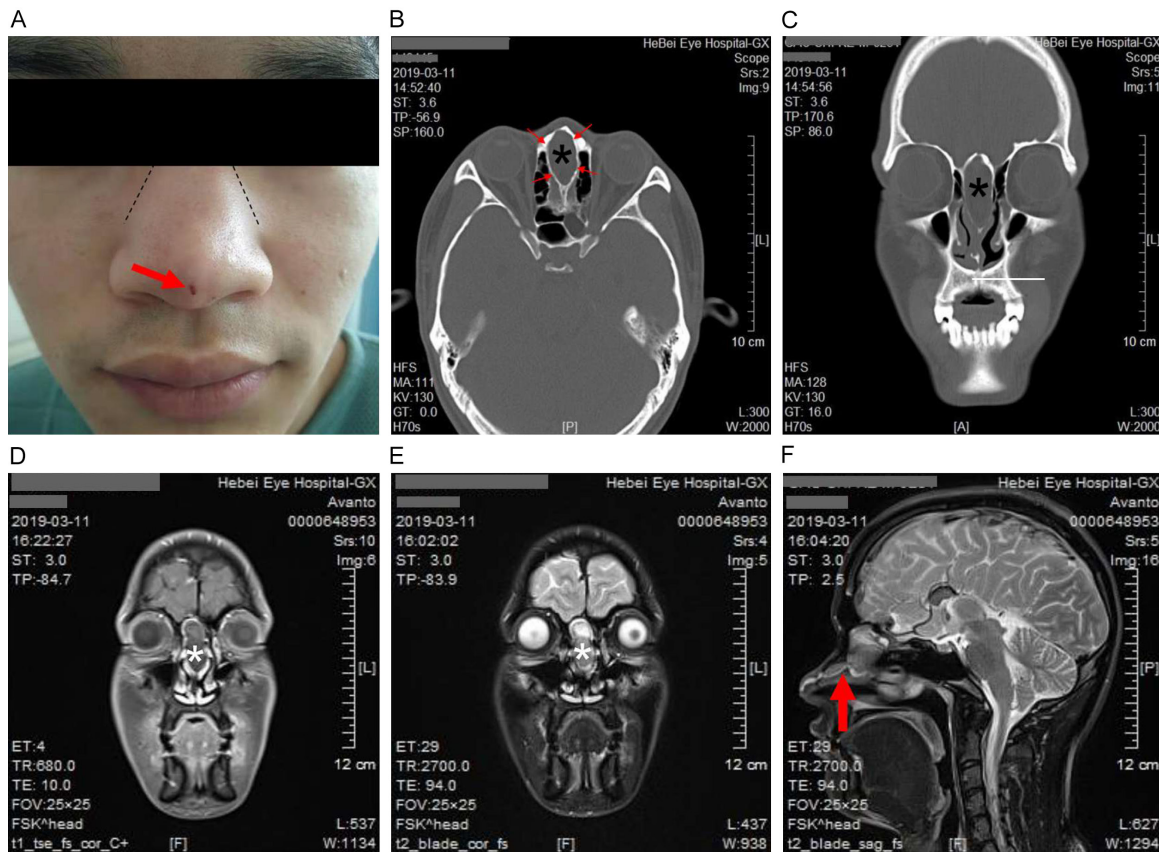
Preoperative clinical findings and multimodal imaging evaluation. A. Black dashed lines delineate expansion of the nasal dorsum overlying the mass. The red arrow indicates a small midline fistula at the nasal tip, representing the external opening of the congenital sinus tract; B. Axial CT image shows an expansive, oval-shaped, low-density lesion (asterisk) in the nasal septum. Red arrows indicate the intact bony shell surrounding the mass. C. Coronal CT view shows a large cyst (asterisk) occupying the perpendicular plate of the ethmoid bone, with marked bilateral septal bulging and narrowing of the nasal airway; D. Coronal contrast-enhanced T1WI displays a non-enhancing midline mass (asterisk); E. Coronal T2WI-fat-suppressed image (T2WI-FS) demonstrates a hyperintense cystic lesion (asterisk); F. Sagittal T2WI image indicates a tubular tract (red arrow) extending from the crista galli to the nasal tip, without intracranial communication.
